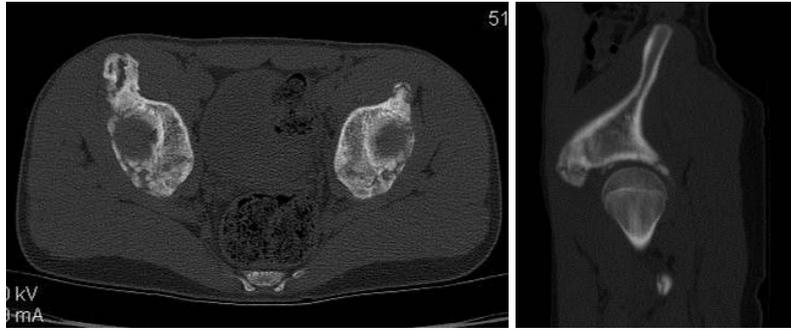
Axial and sagittal CT scans revealing the ossification located on the anterior side of the iliac crest.
